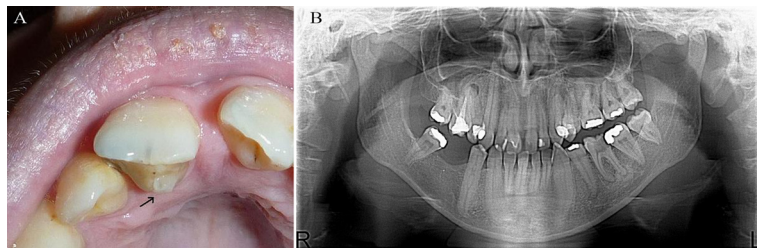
A, Intraoral photograph of the twins' mother showing talon cusp of the maxillary right central incisor. B, Orthopantomogram of the twins' mother.
